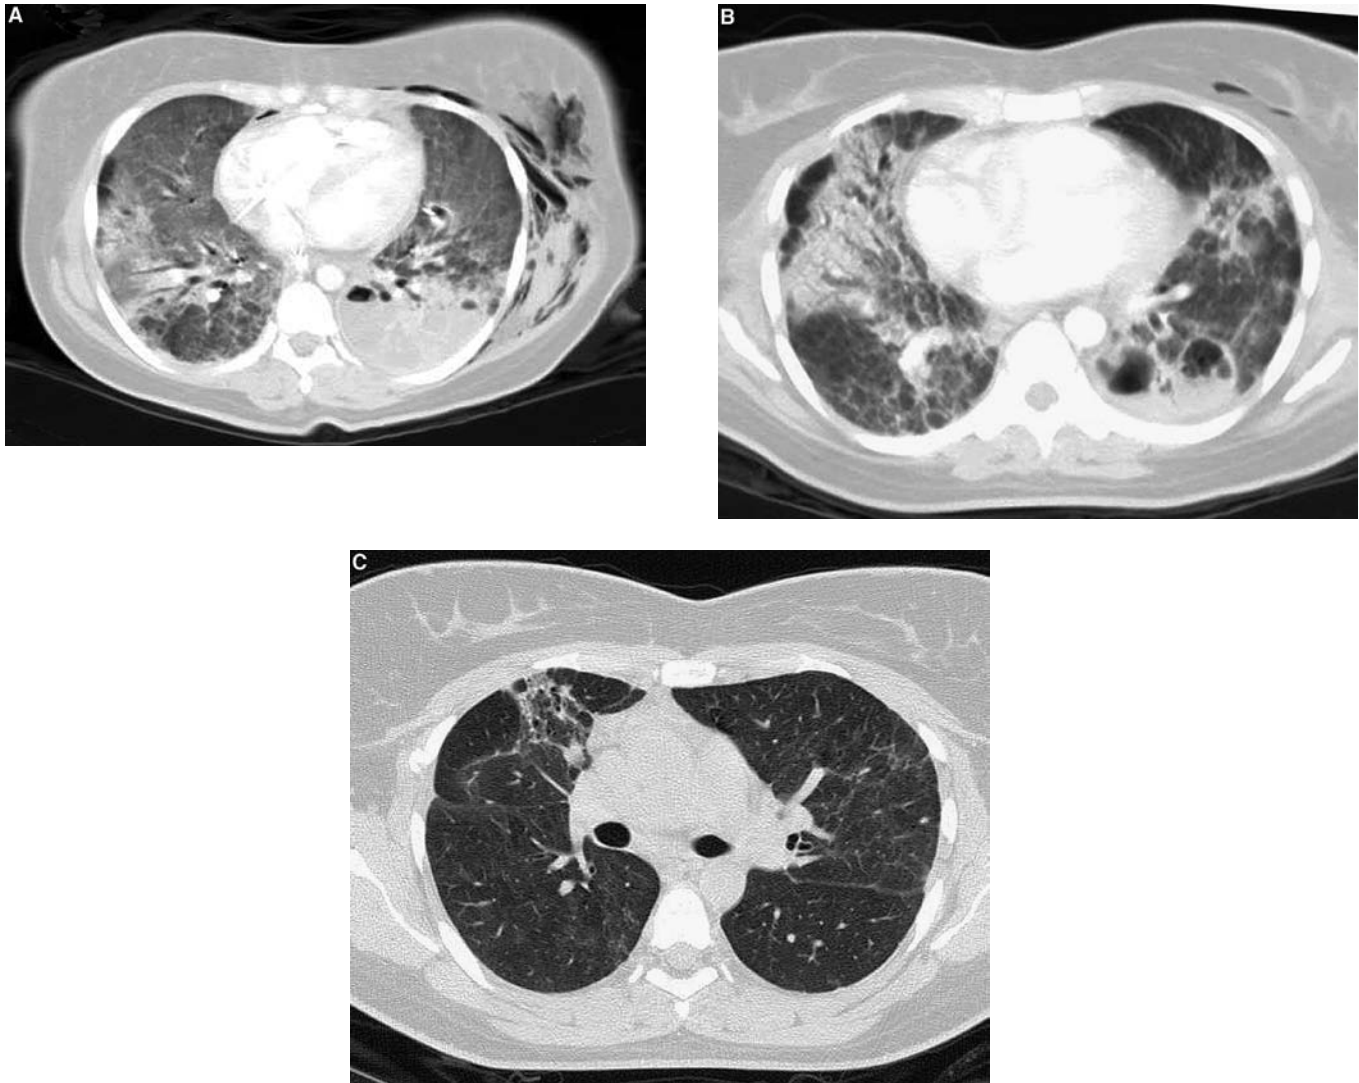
Sequential chest CT scans of a 39-year-old female with ARDS due to acute pneumococcal pneumonia. *A*, First scan, 6 days after onset. Note the diffuse ground-glass opacification, consolidation with early abscess in the left lower lobe, and subcutaneous emphysema in the left lateral chest soft tissue. *B*, Three weeks after onset: note increased heterogeneity in opacities, abscesses in the left posterior lung and cystic spaces in the right posterior lung. *C*, Scan taken just under 4 months after onset, showing residual irregular fibrosis in the right anterior lung field. The patient was then at home, asymptomatic, and had normal pulmonary function test findings.
